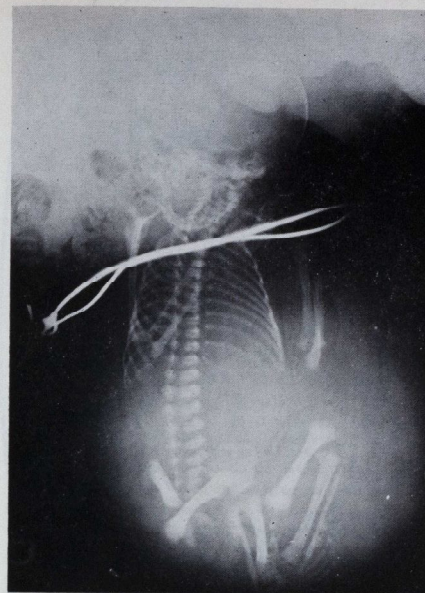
Lateral X-ray showing Foetus in Hernial Sac.
